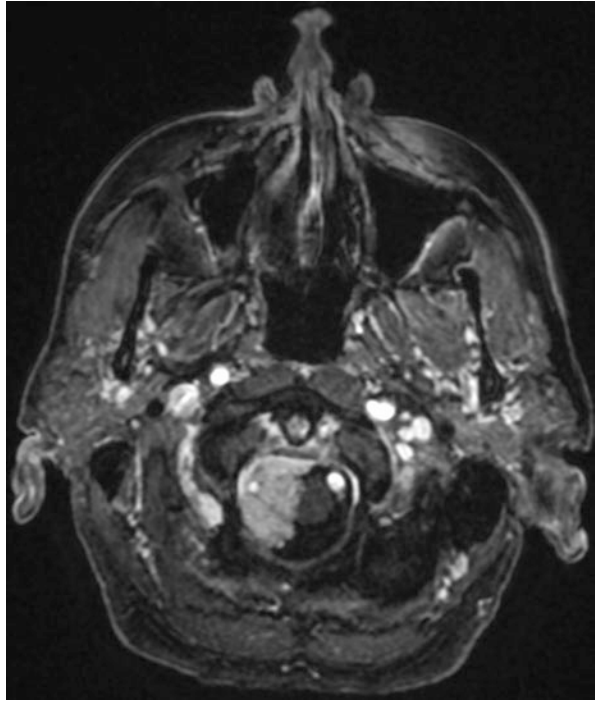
Coronal view in same patient as in Fig. 27.1 of right-sided, laterally localized FMM, with complete encasement of the (non-dominant) right vertebral artery. T1-weighted Gd-enhanced imaging clearly shows the dural attachment and the venous sinuses. All this is relevant for planning of the surgical approach, and for preparation of material for vascular repair
